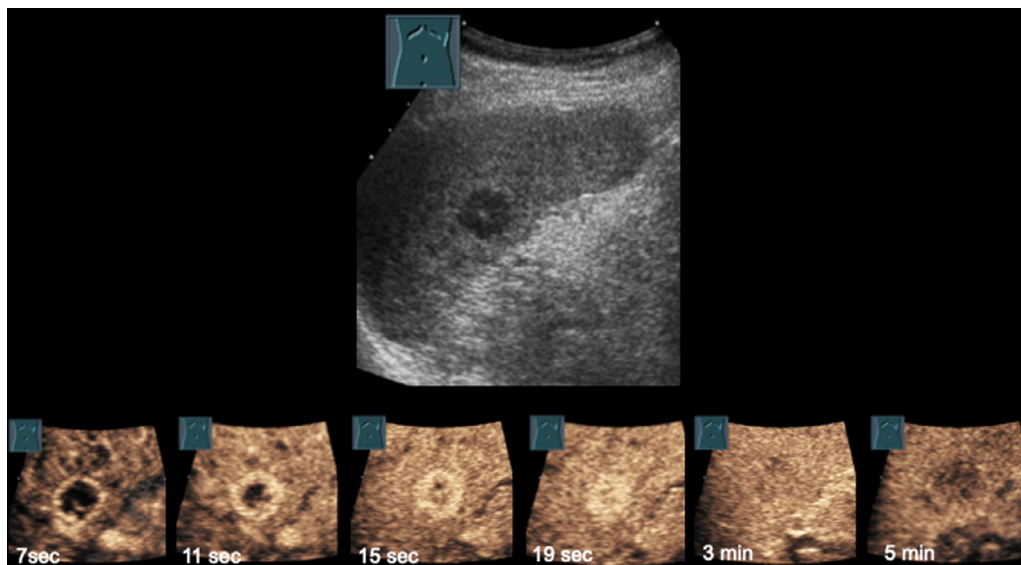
Hypoechoic, accidentally detected focal splenic lesion in B-mode ultrasound. In CEUS, the lesion shows an early arterial-peripherally beginning, enhancement (“high flow” pattern). Parenchymal the lesion shows a long-lasting enhancement with hypoenhancement in the parenchymal phase. This finding is indicative of a hemangioma or splenoma.
